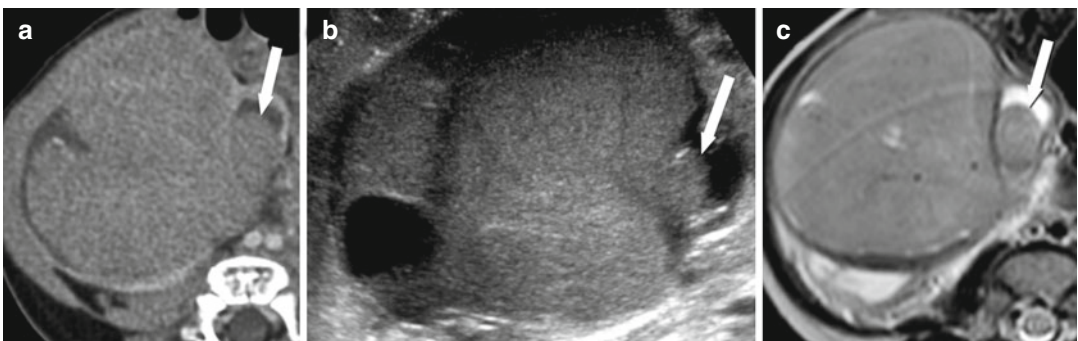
A large right renal mass invades the renal collection system and proximal ureter. Images with three different modalities: CT (a), ultrasound (b), and T2-weighted MRI (c) all demonstrate the tumor-urine interface (arrows)
